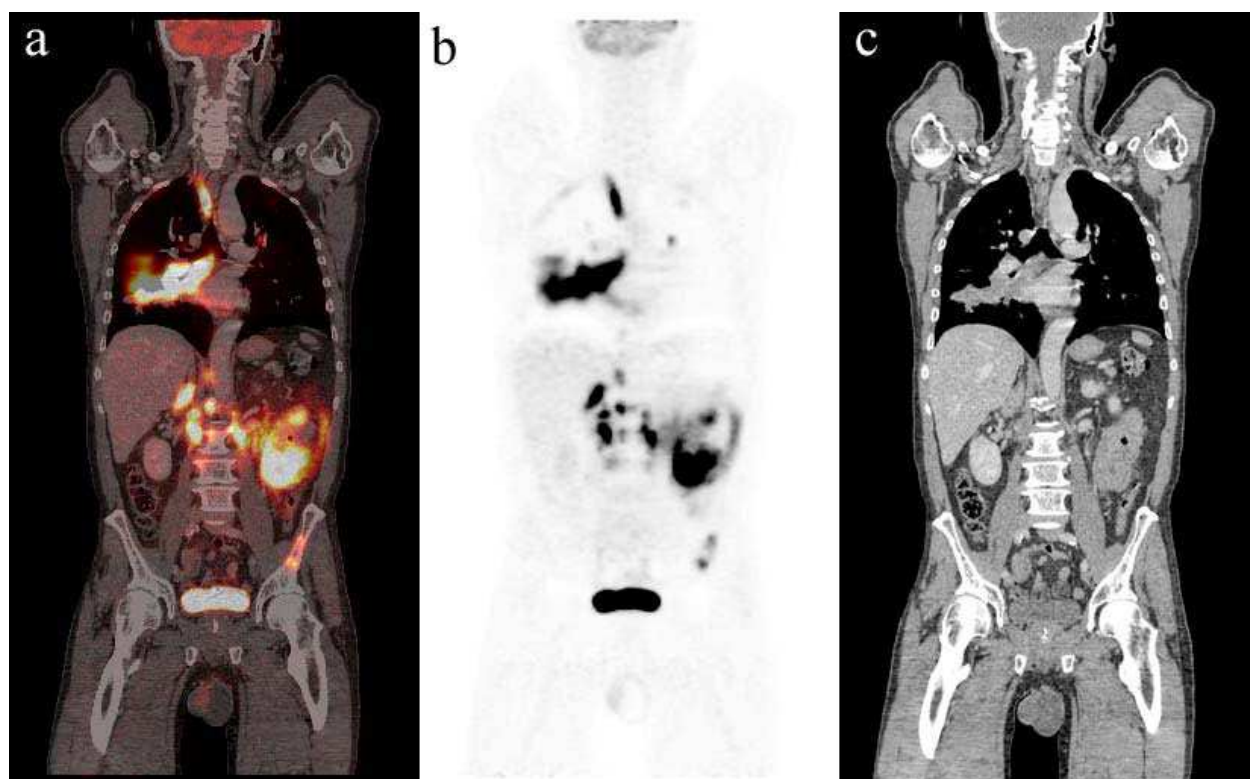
A coronal slice of fused PET/CT image (a), the corresponding PET image (b) and CT image (c) in a 62-year-old male patient with diffuse large B-cell lymphoma. Multiple FDG avid lesions are showing in the cervical, mediastinum, abdominal region, and the left iliac on both the fused PET/CT image and the PET image. The iliac lesion was neither detected by the corresponding CT image, nor by bone marrow biopsy that was performed at the right side of the iliac.
